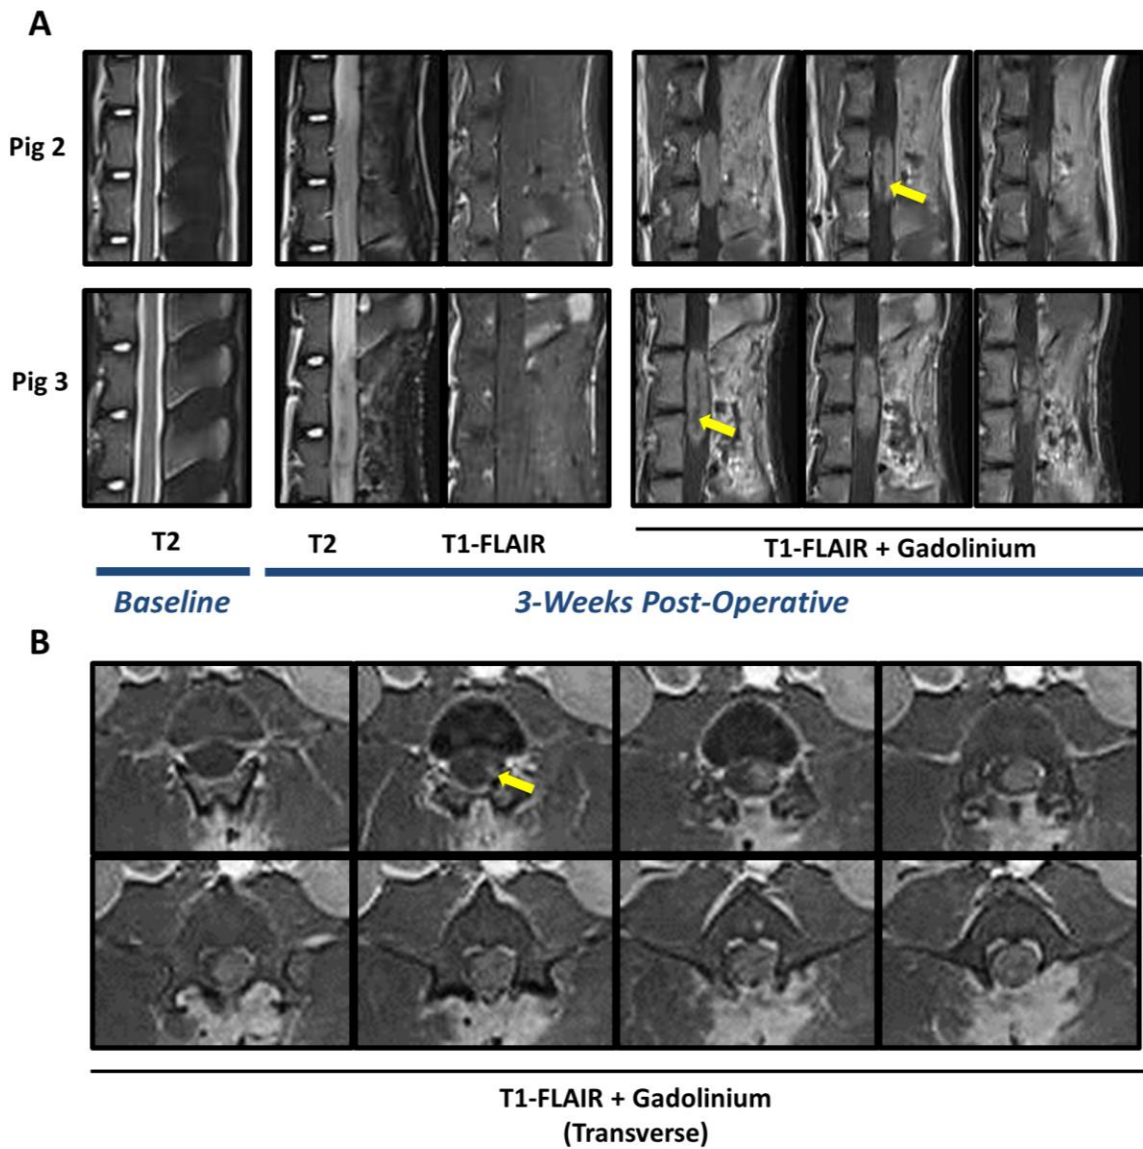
Endpoint MRI scans demonstrate mass forming lesions consistent with high-grade intramedullary spinal cord glioma.
